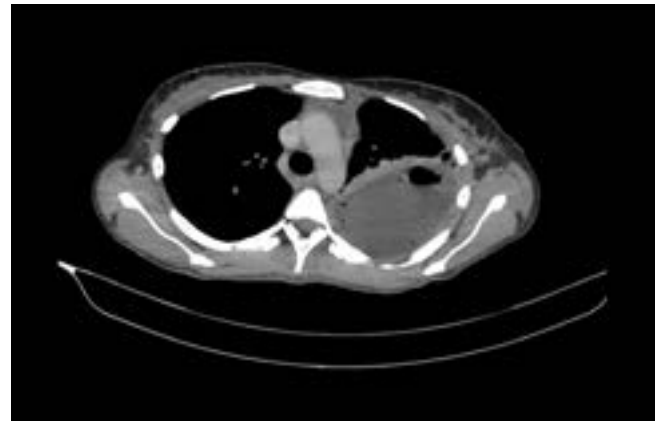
CT chest axial view with organized loculated left pleural effusion with a split pleura sign.
